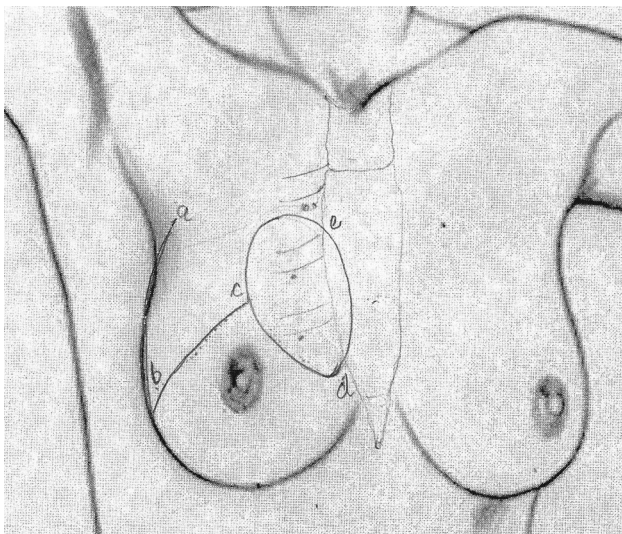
Parasternal skin paddle of PMMC flap (*cde*) planned over 3rd and 4th intercostal perforators and lateral fasciocutaneous breast flap (*abc*) based on 2nd intercostal perforator
